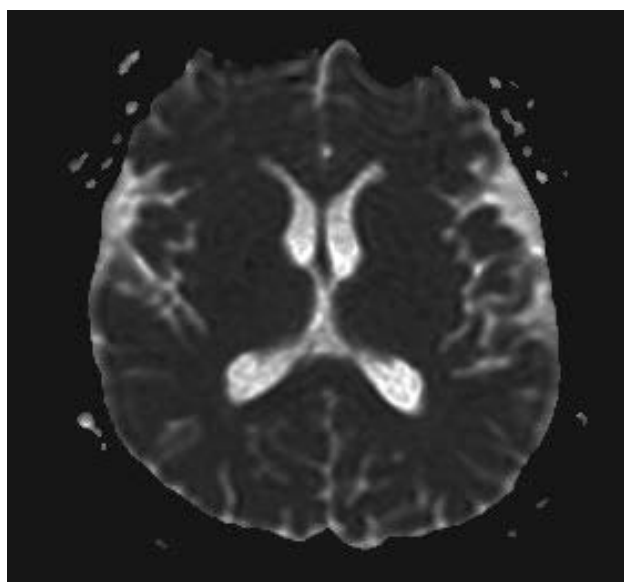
MRI of the brain, ADC/DWI – total regression of hyperintense lesions: a) MRI of the brain, DWI; b) MRI of the brain, ADC.
